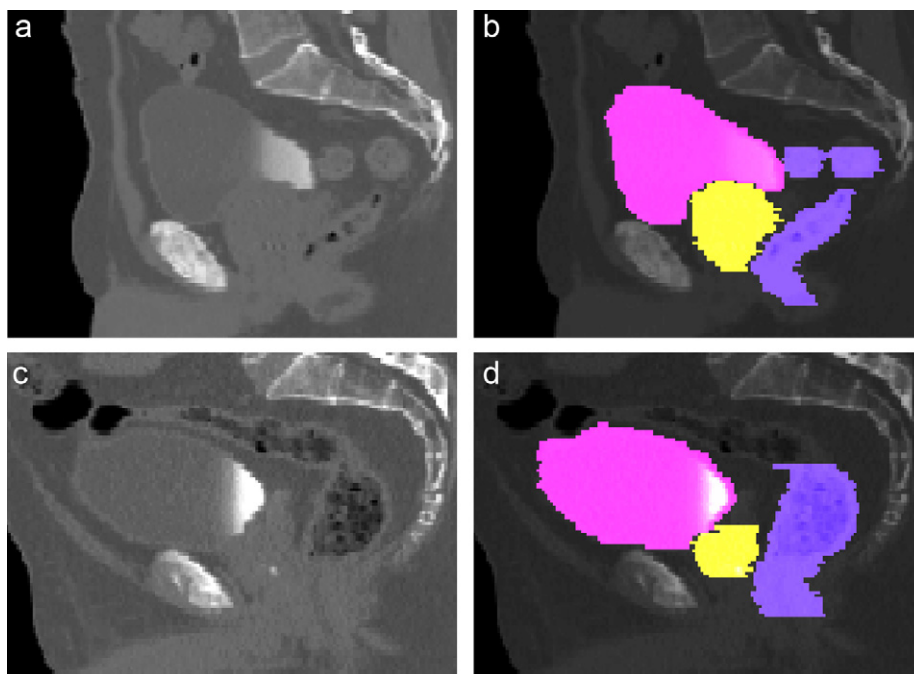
Example of two computed tomography (CT) sagittal views (a and c) with the delineated organs (b and d): prostate (yellow), bladder (pink) and rectum (mauve).
